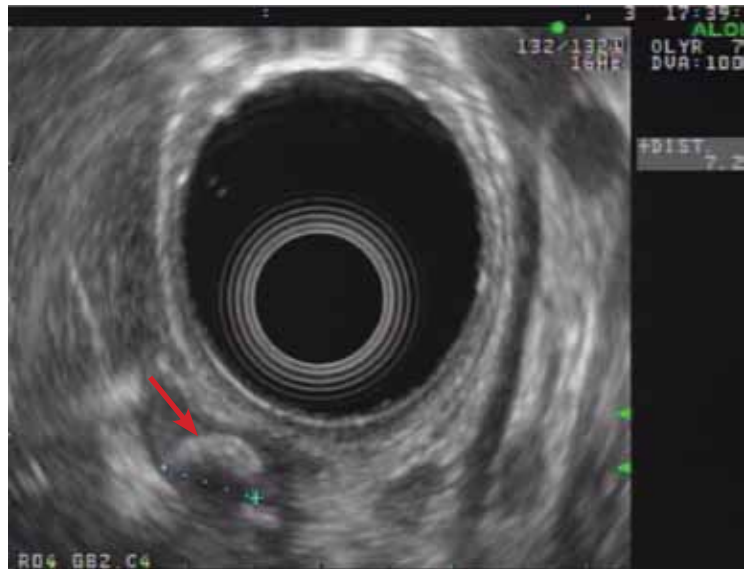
Endoscopic ultrasonography from the duodenal bulb shows a 7-mm stone (arrow) in the cystic duct remnant or gallbladder remnant.
